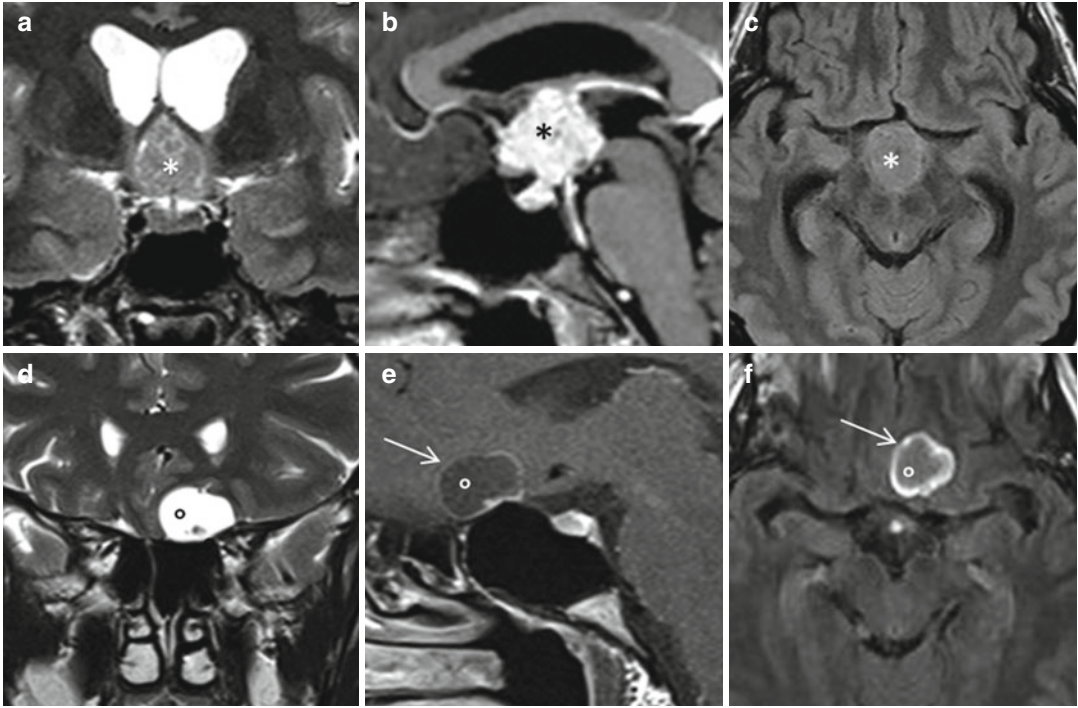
A 43-year-old woman with headaches. Suprasellar papillary craniopharyngioma with recurrence 1 year after surgery away from suprasellar region, along the surgery path. (a) Coronal T2WI. Isointense suprasellar mass (*asterisk*). (b) Sagittal CE T1WI. Reticular diffuse enhancement (*asterisk*). (c) Axial FLAIR WI. Homogeneous isointense signal (*asterisk*). One year after
